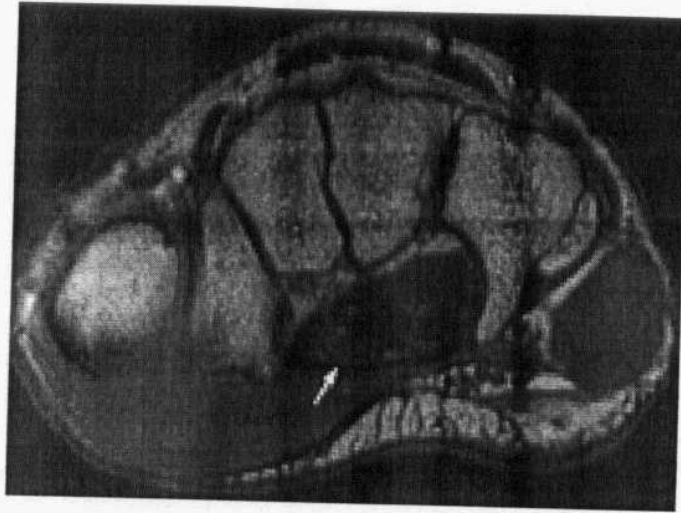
Transverse T1-weighted at the level of the hook of the hamate demonstrate visibility of the median nerve (arrow)(Quoted from Nadja Saupe, et al.,2005).
